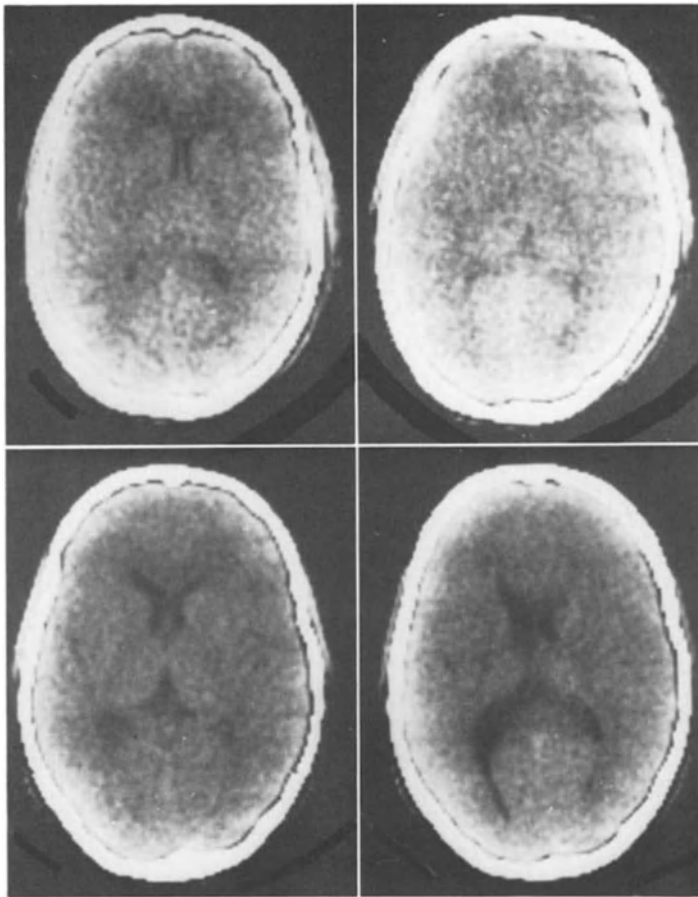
This 12 year-old boy was injured in a traffic accident. The GCS score on admission was 13 points and the CT scan showed generalized brain swelling (upper left). Six hours after admission sudden neurological deterioration occurred (score = 7). A control CT scan showed increased diffuse brain swelling (upper right). Initial ICP was 45 mmHg but could be easily controlled with hyperventilation and mannitol. The patient recovered consciousness within few days. A further CT scan performed 9 days after injury showed reexpansion of the CSF spaces (lower). The final outcome was good recovery
